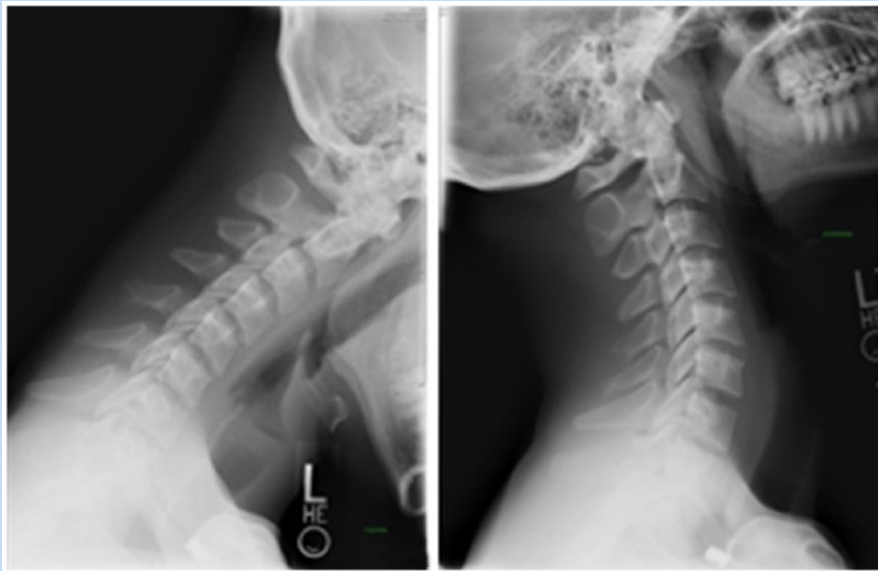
Flexion-extension radiographs at follow-up examination. Torg ratios: C3, 0.69; C4, 0.79; C5, 0.93; C6, 0.90; C7, 0.80.
